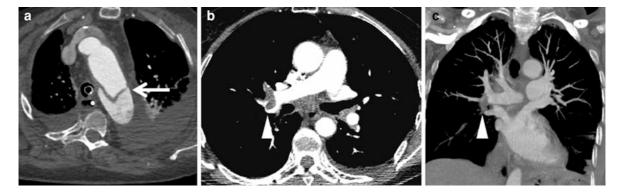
a CT angiography of the thoracic aorta which demonstrates a dissection (*arrow*) along the aortic arch/descending aorta. b CT angiography of the pulmonary arteries in evaluation
